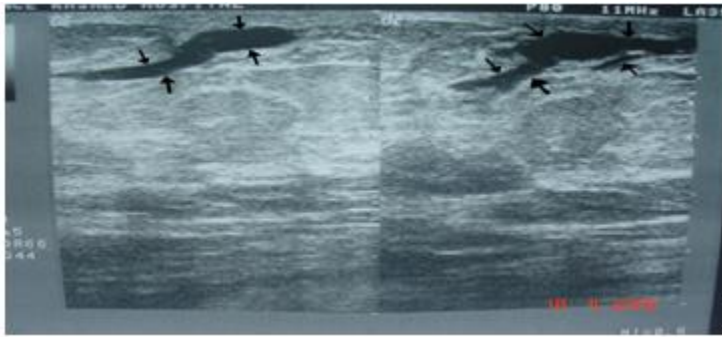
Breast Ultrasound Showing Tubular and Elongated Echo-free Structures
